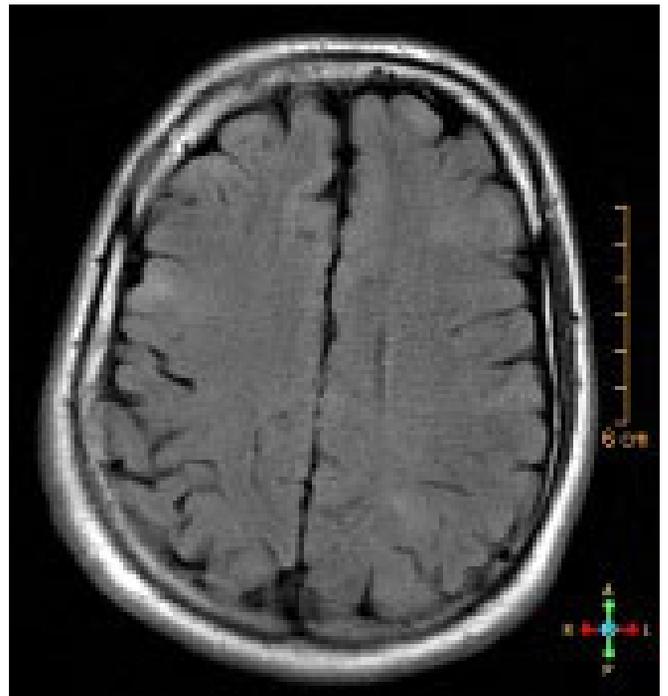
Tuberous sclerosis. MRI demonstrates multiple cortical and subcortical supratentorial lesions (tubers).
